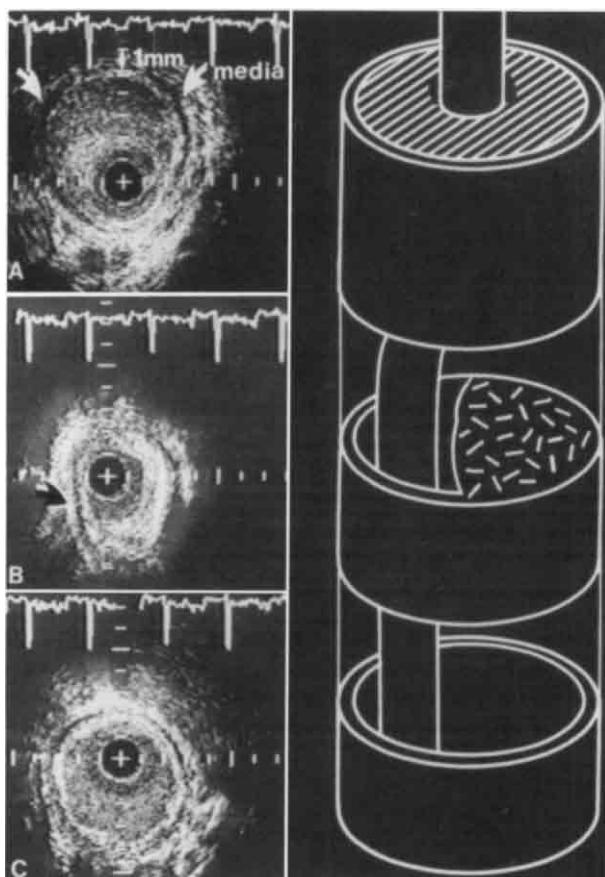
Ultrasound images obtained *in vivo* from a femoral artery, following laser angioplasty. (Courtesy of Dr. E. Gussenhoven.)
